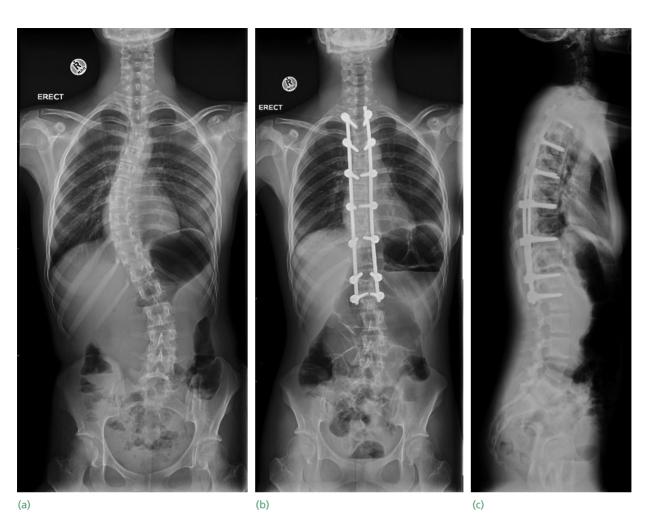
Scoliosis – posterior instrumentation (a) Preoperative anteroposterior X-ray; (b) postoperative anteroposterior X-ray; (c) postoperative lateral X-ray.
